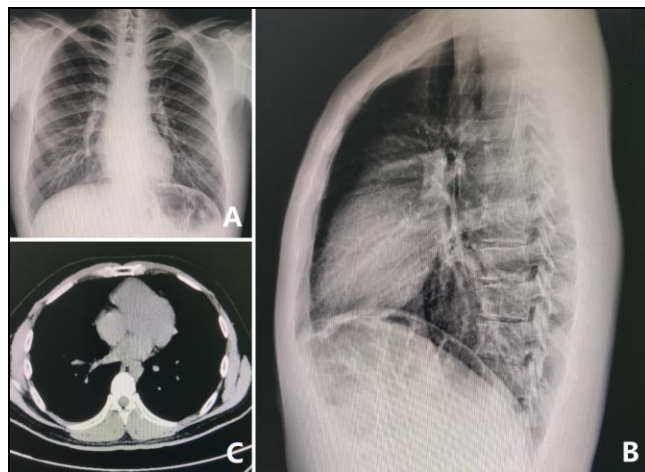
Imaging examination of chest wall. A, B, X-ray examination; C. CT scan examination.
